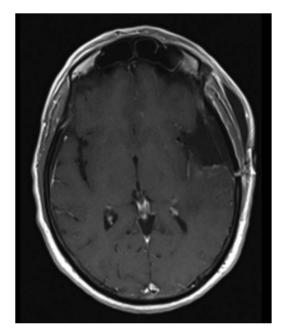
Postoperative brain MRI. Gadolinium-enhanced T1-weighted axial image demonstrating radical tumour excision.
